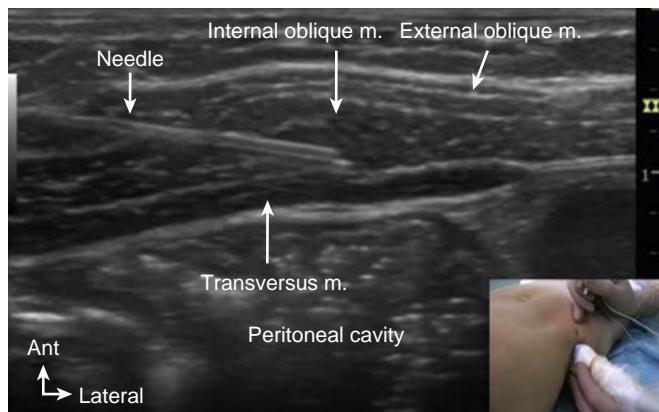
Ultrasound transversus abdominis plane block imaging and probe placement for in-plane needle insertion. m, Muscle.
